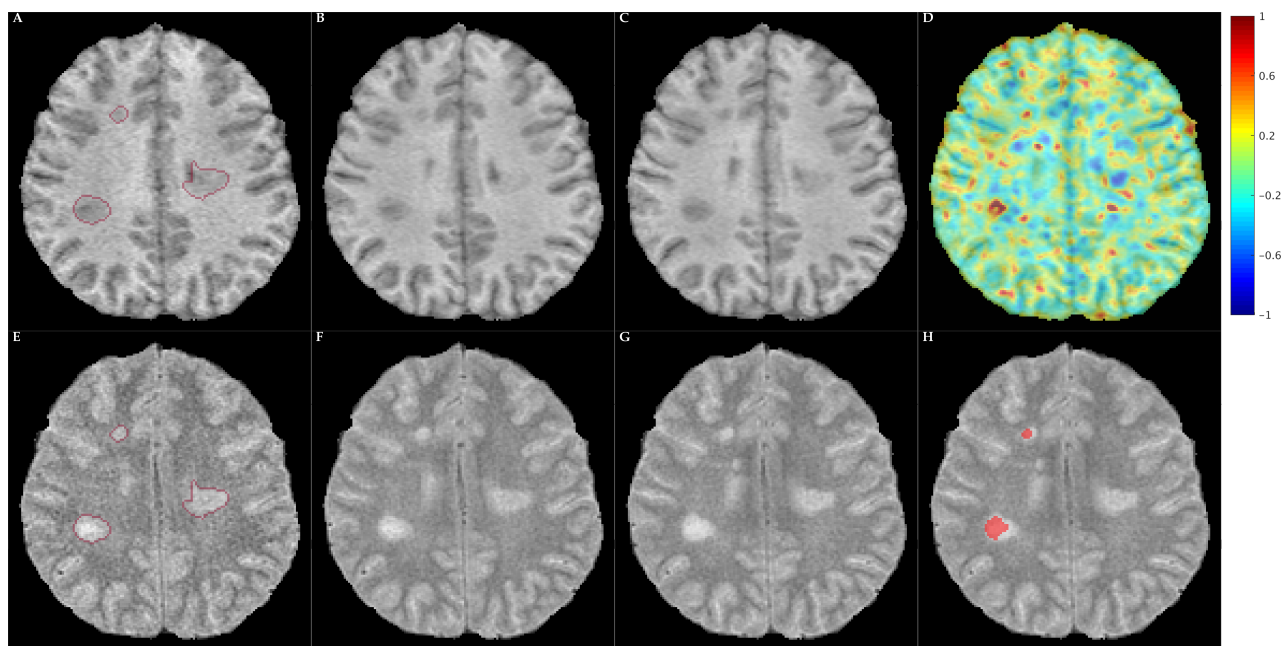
Example slowly expanding lesion (SEL) detection. (A–C): T1-weighted scan at years 1, 2, and 3. (E–G) T2-weighted scan at years 1, 2, and 3. T2 lesions at year 1 are outlined in (A) and (E). (D) Jacobian determinant quantifying local volume change from year 1 to year 3, where positive values denote expansion and negative values denote contraction. (H) Boundaries of detected slowly expanding lesions.
